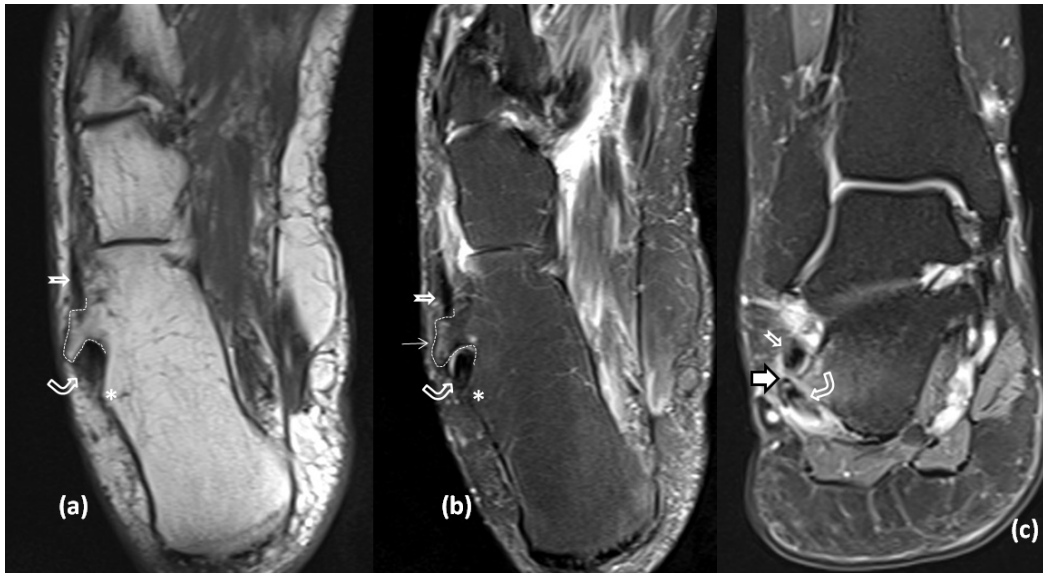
Hypertrophic peroneal tubercle of lateral calcaneus (dashed line) on T1-weighted (a) and fat suppressed T2-weighted (b) images of a 70-year-old male patient. The hook-like bony prominence is separating peroneus longus (curved arrow) and peroneus brevis (open arrow) tendons. Note the mild subcortical bone marrow oedema (thin arrow in b) in the hypertrophic peroneal tubercle. The retrocalcaneal eminence (asterisk) lies posterior to the peroneal tubercle. In another 52-year-old female patient with lateral ankle pain, the prominent peroneal tubercle with its pointy tip (thick solid arrow) and accompanying bone marrow oedema are shown on this coronal fat suppressed proton density image (c). Note that in this patient there is tenosynovitis and partial thickness tear in the peroneus longus tendon (curved open arrow). The peroneus brevis tendon is normal (short open arrow).
